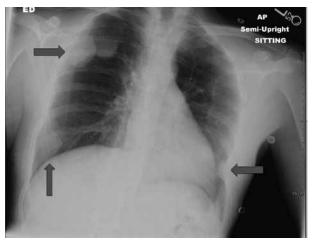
Chest radiograph shows multiple round softtissue densities, which appear to be pleural based, growing from the ribs in bilateral hemithoraces.
